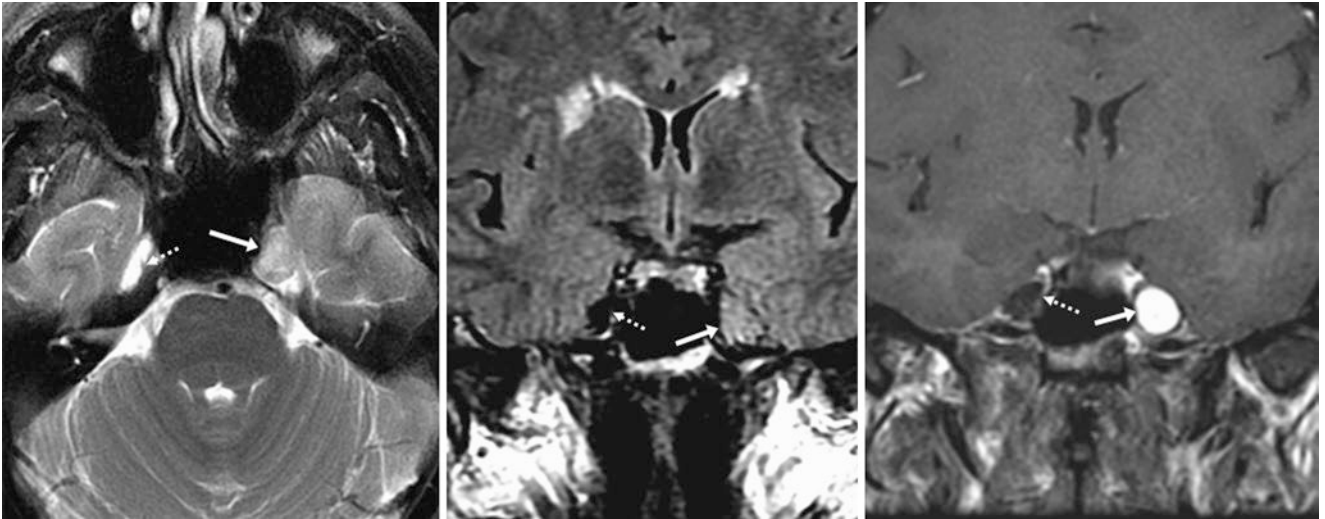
Comparison case of meningioma. A 58-year-old patient had a left-sided enhancing mass within Meckel cave (*arrows*) on 1.5 T MRI axial T2WI (*left*), coronal FLAIR (*middle*), and coronal fat-suppressed
